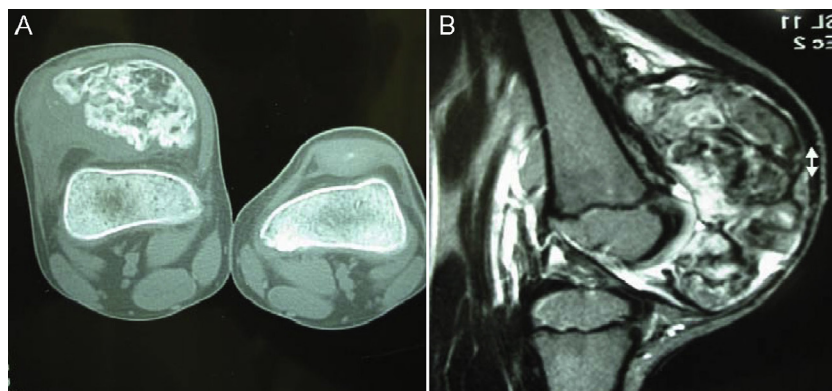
Preoperative appearance on axial computed tomography slice (A) and on T2-weighted sagittal magnetic resonance slice (B) of the right knee with voluminous patellar tumor formation, immediately before surgery: hemimelic epiphyseal dysplasia.
